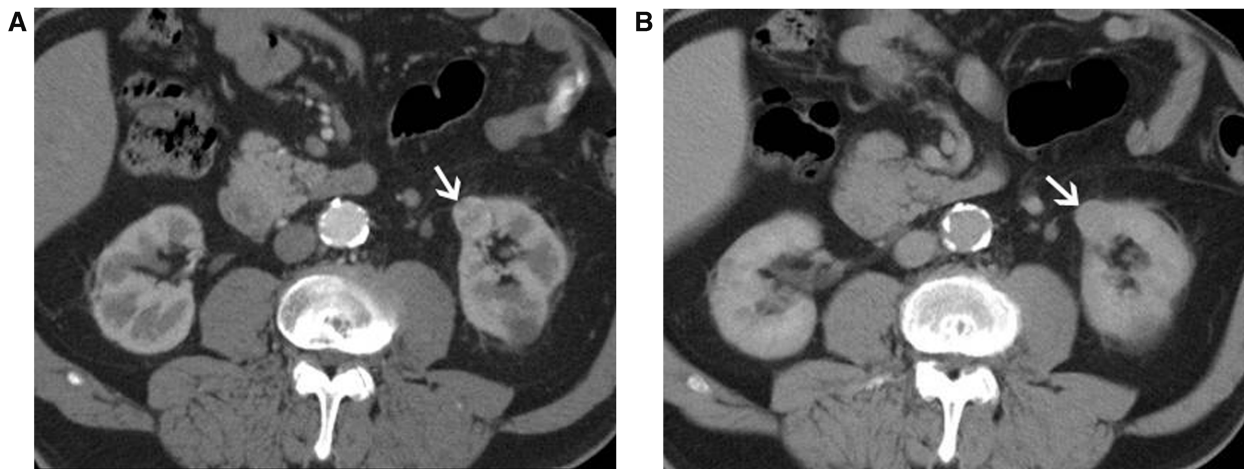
Oncocytoma. Axial contrast-enhanced CT images demonstrate an enhancing mass (arrow) in the corticomedullary phase (a) and nephrographic phase (b) which cannot be distinguished from renal cell carcinoma.
